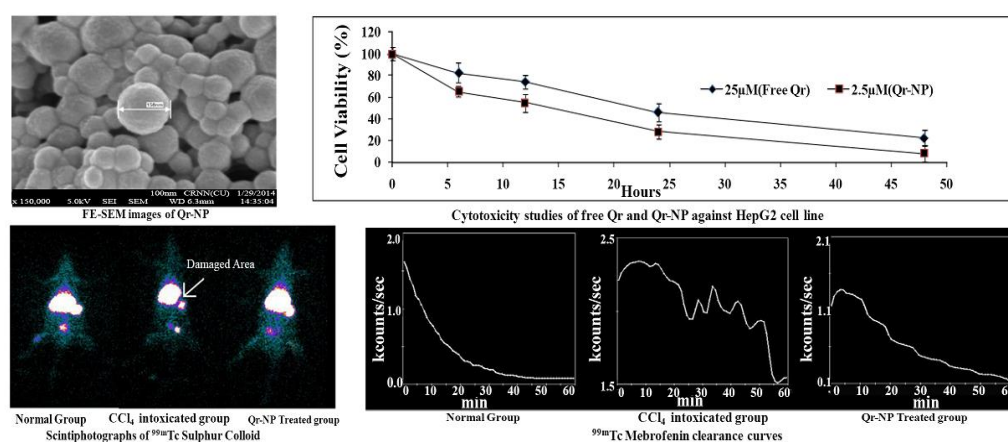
The hepatoprotective efficacy of Qr-NPs evaluated non-invasively by nuclear scintigraphic technique using ^{99m}Tc -labeled sulfur colloid and ^{99m}Tc -labeled mebrofenin
